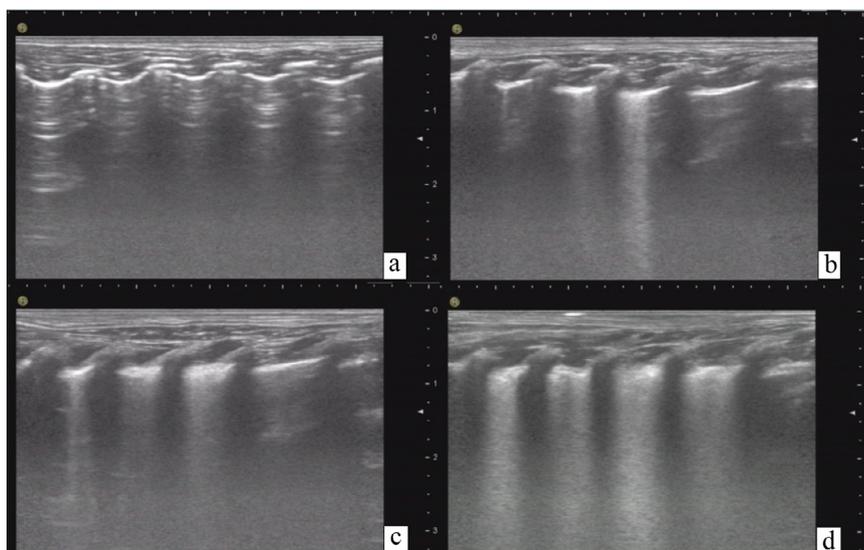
Ultrasound images of the lungs. (a) Control group; (b) mild group; (c) moderate group; (d) severe group. Only a few scattered B-line artifacts were detected in the control group, whereas a large number of diffuse B-line artifacts were detected in the pulmonary edema groups.
